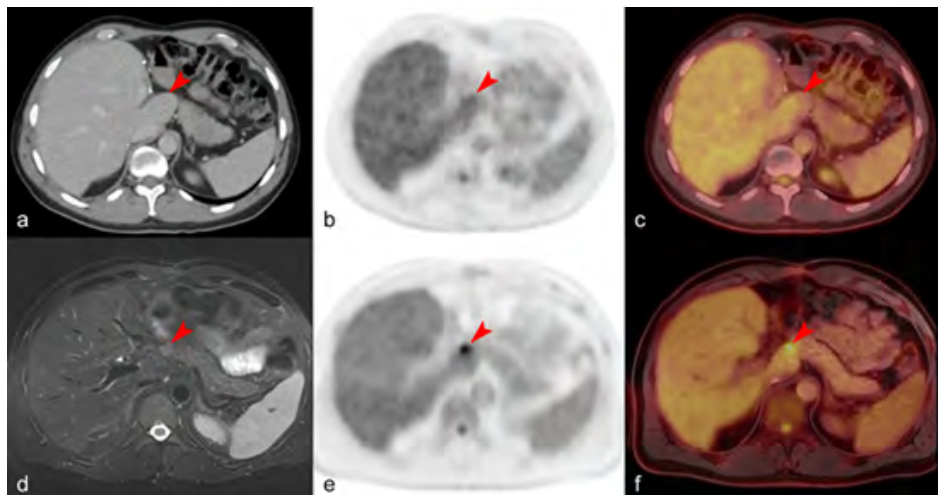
65-year-old male with colon cancer metastatic to liver, with small lesion in segment 1 of the liver. The lesion is not visualized on PET or CT of PET/CT (a,b) including fused images (c). The hepatic lesion is clearly seen on PET/MR on both MR (d), PET (e), and fused PET/MR images (f).
